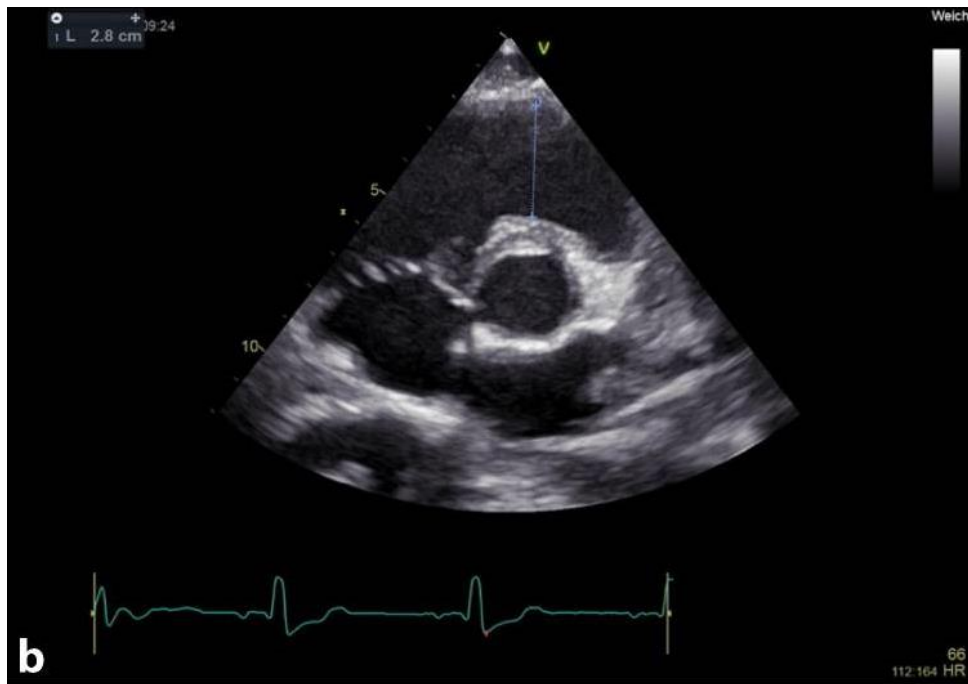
Proximal human right ventricular outflow tract on the parasternal short-axis view (normal range is 21-35mm).
